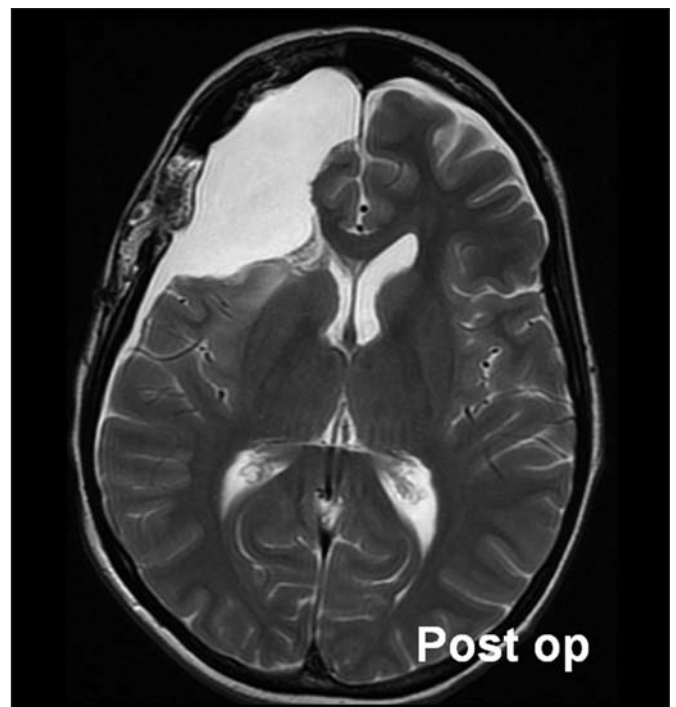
Axial T2-weighted image (by 1.5 Tesla GE Sign Excite). Post surgery, no pathological tissue is seen.
